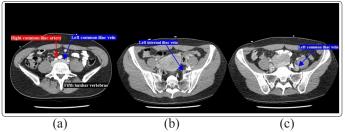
Abdominal CT venography: right common iliac artery crossing anteriorly to the left common iliac vein in (a) showing features consistent with the MTS. (b) and (c) demonstrate the thrombosis (white arrow) formed in the internal iliac vein extending to the common iliac vein distal to the compression by the right common iliac artery
